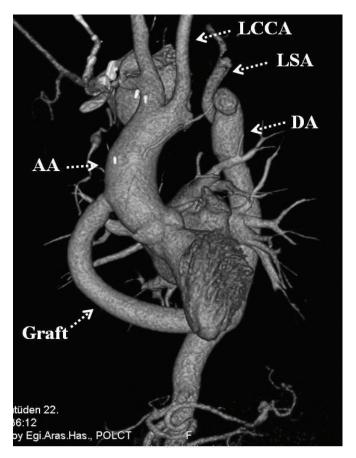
Postoperative 3-dimensional reconstructed computed tomography image shows the interruption of the aortic arch and ascendingto-descending aortic bypass graft. LCCA indicates left common carotid artery; LSA, left subclavian artery; DA, descending aorta; AA, ascending aorta.
